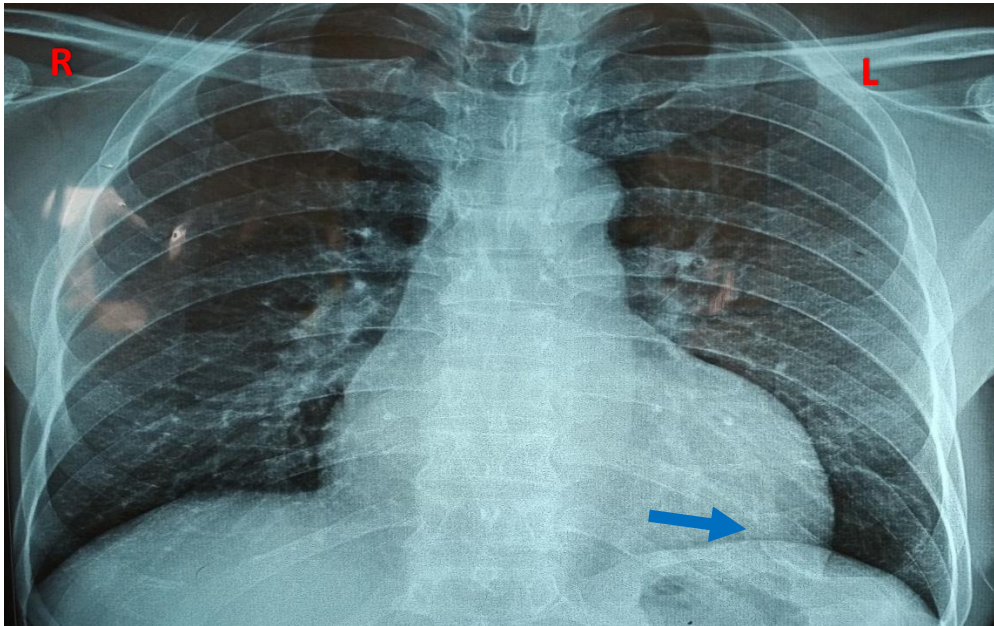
Frontal chest X-ray: rounded opacity well limited to the level of the lower lobe of the left lung without filling of the left costo-diaphragmatic cul-de-sac or parenchymal abnormality (arrow).
